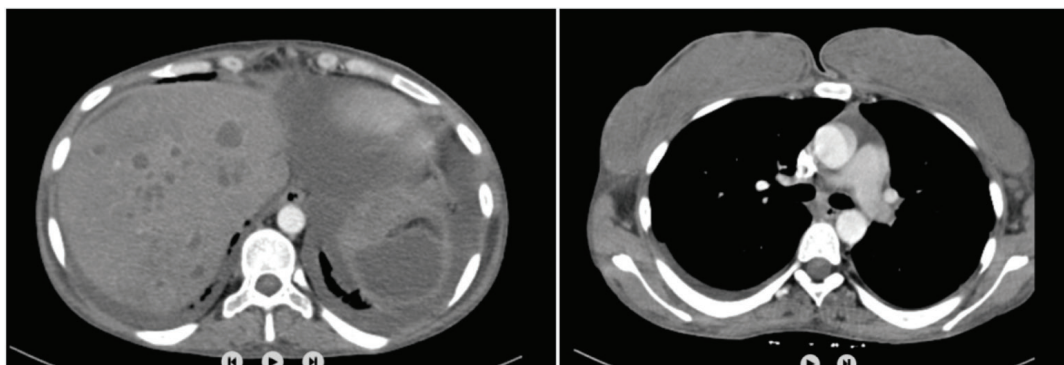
CT Images 2 weeks after starting steroid therapy (marked improvement in abscesses and effusions)
